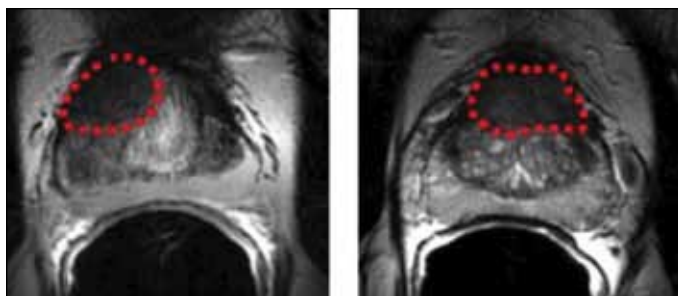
Magnetic resonance imaging reveals large anterior tumour. Dotted outline indicates the tumour.
